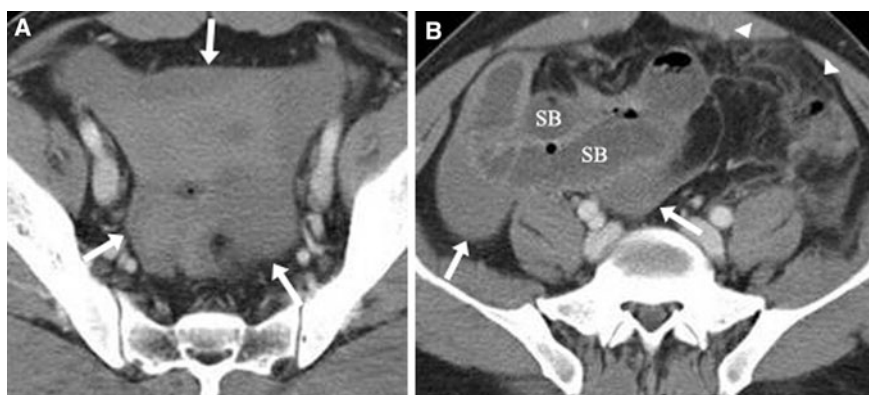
A 32-year-old male status post-blunt abdominal trauma. A Axial contrast-enhanced CT of the pelvis demonstrated a large amount of free fluid (*arrows*) in the absence of solid organ injury. B Axial contrast-enhanced CT of the upper pelvis
